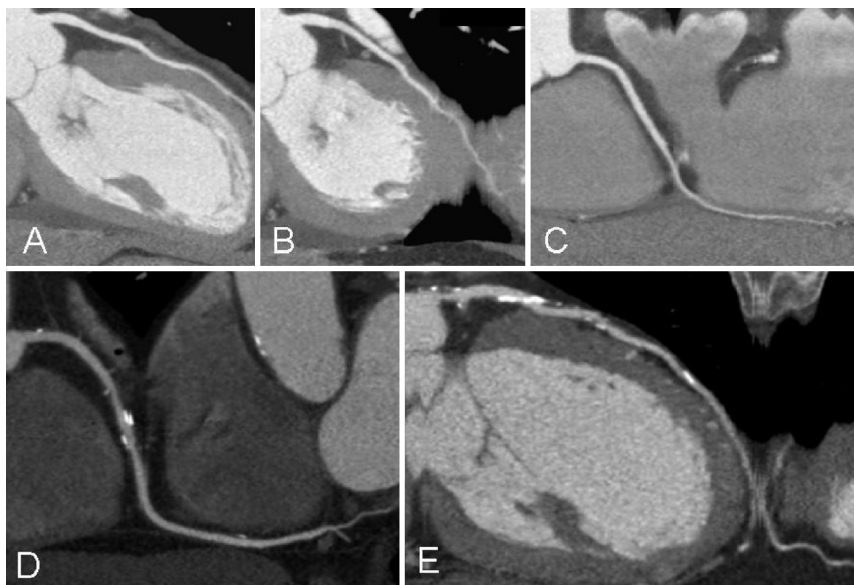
Examples of different multi-slice computed tomography observations (A, B, C). Curved multiplanar reconstructions of, respectively, the left anterior descending coronary artery (LAD), left circumflex coronary artery, and right coronary artery (RCA) of a patient with normal coronary arteries are provided. (D) Curved multiplanar reconstruction of the RCA is provided, showing diffuse coronary artery disease without obstructive lesions. (E) Stenosis of the left main coronary artery as well as proximal LAD can be observed.
